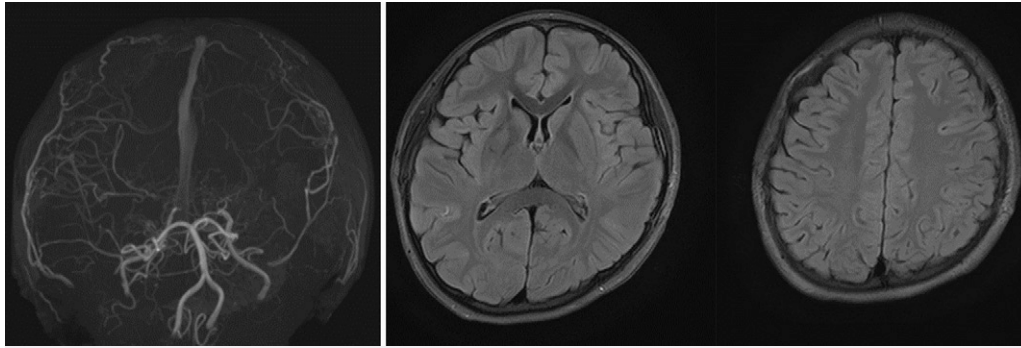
MRI/MRA 3 months after revascularization. MRA showed that a vascular channel from the external carotid system had developed and that the MMVs on the left side had regressed (left). No new stroke was found until it developed as a chronic phase on MRI (right).
